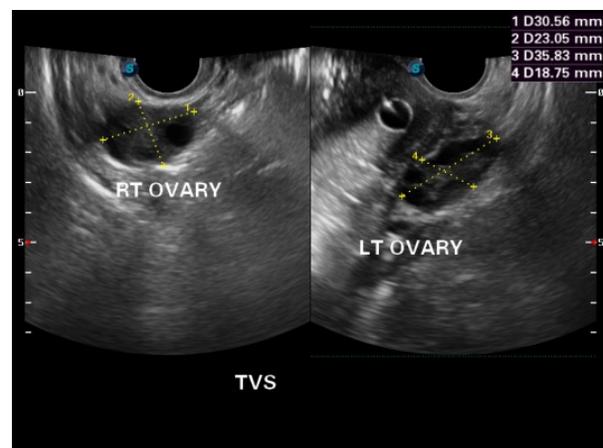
Transvaginal (TVS) ultrasound image of ovaries rarely showing any follicles in infertile group
